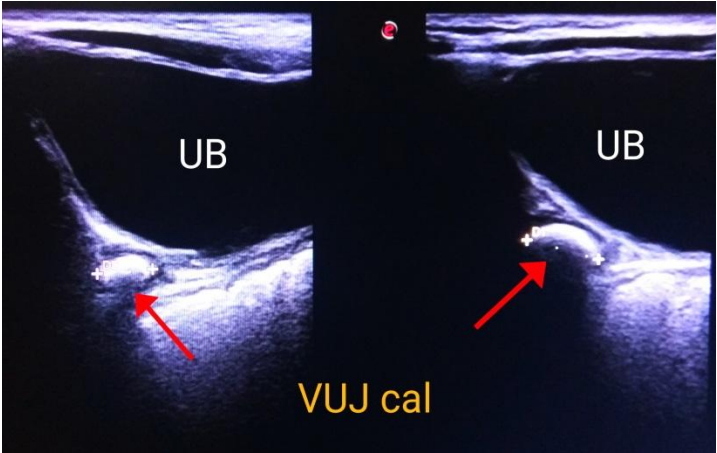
Ultrasound image showing ureteral calculi.
